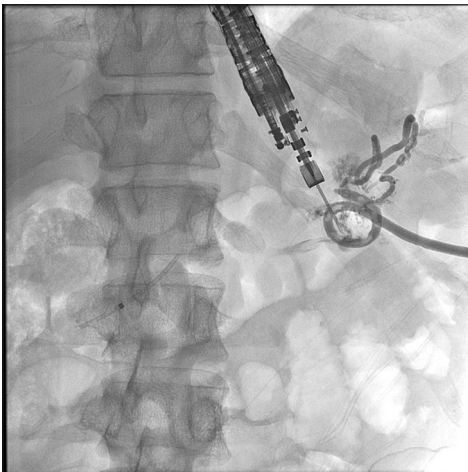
Fluoroscopic image. Percutaneous drain transgastric puncture under endosonographic guidance with pancreatogram of the tail of the pancreas and a small cavity around the drain
